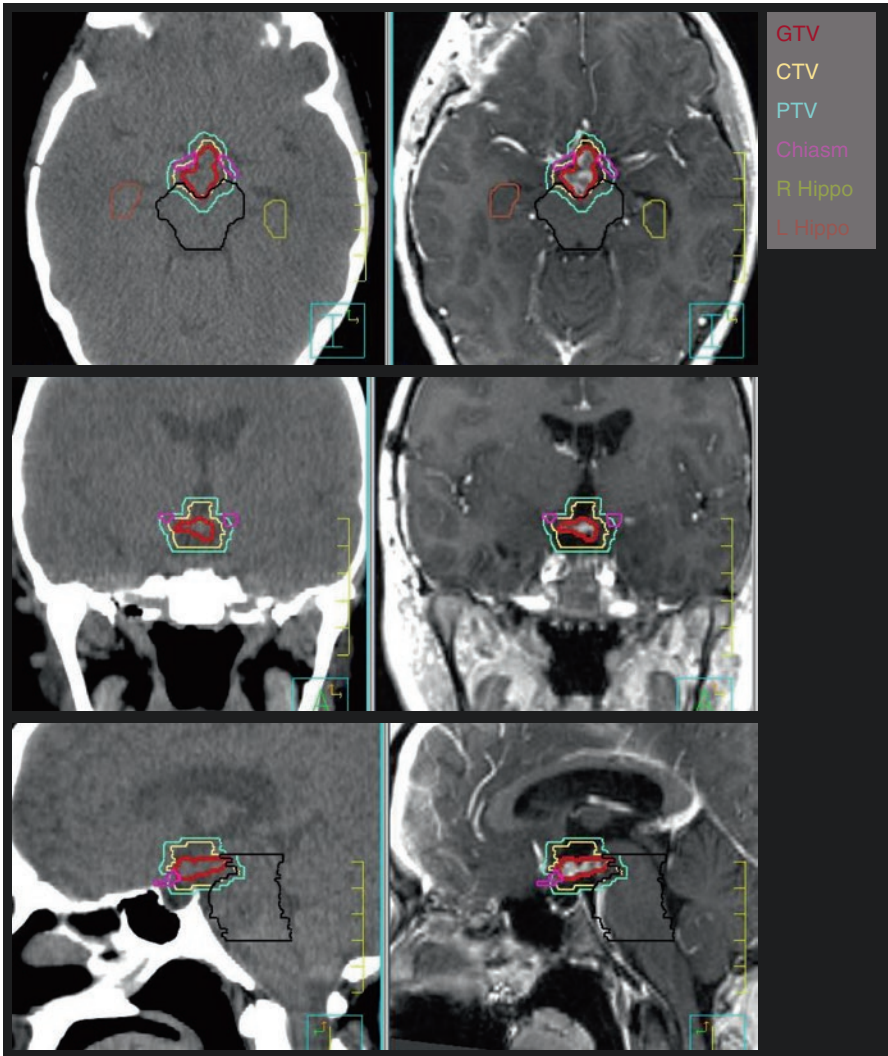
Case 1. Postoperative axial, coronal, and sagittal MRI imaging demonstrating residual enhancing disease in close proximity to the optic apparatus, hypothalamus, and brainstem
